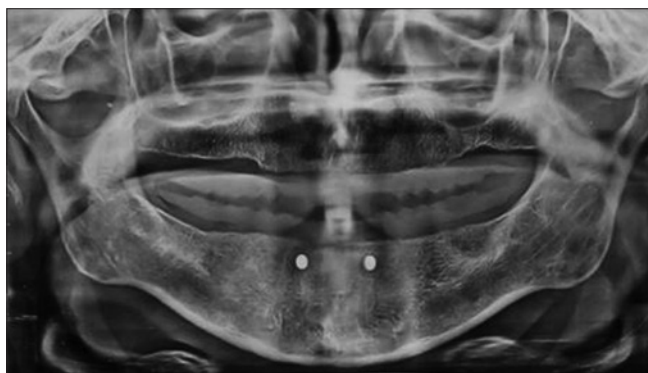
Orthopantomogram showing steel balls in B and D location
